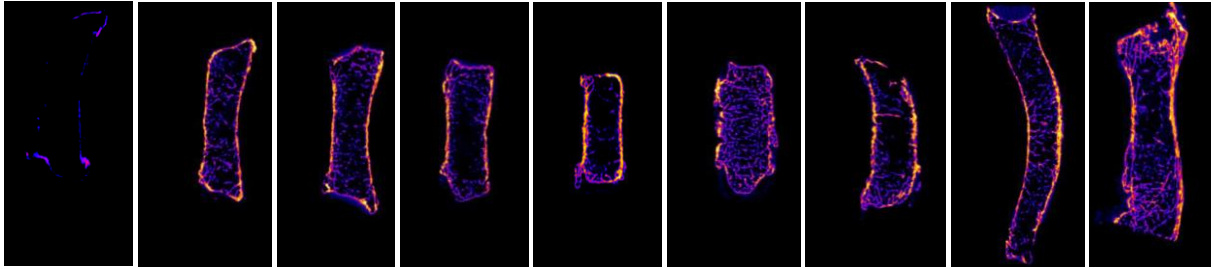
CAD162, example of sternum cross sections ventral to coronal from the μ CT-Scan (left to right). Step approx. 1 cm
